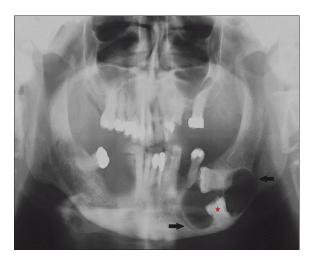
An orthopantomogram showed large radiolucent unilocular cyst in the left mandibular body associated with an unerupted molar tooth (asterisk). The inferior dental nerve canal (black arrows) is noted to be traversing the cyst cavity
